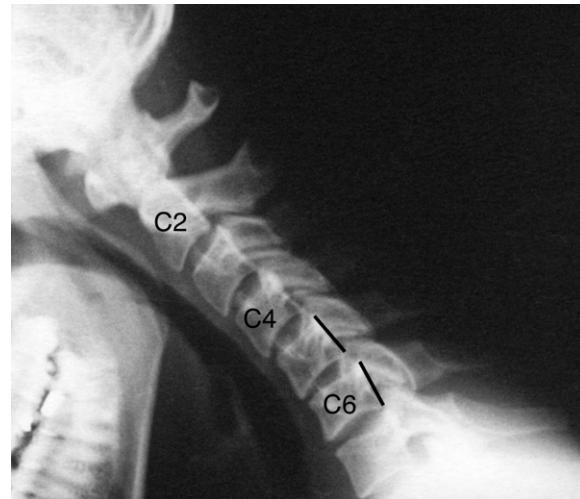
Cervical spine flexion plain X-ray image. Note the angulation at the C5–6 level (as indicated by the two black lines).
